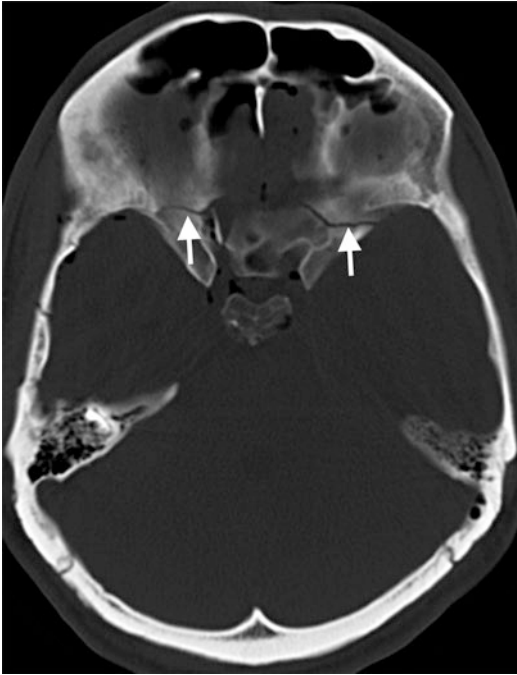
Axial CT image of a 31-year-old man with MVA reveals a linear fracture (arrows) traversing bilateral lesser sphenoid wings and posterior orbital plate of the frontal bone
